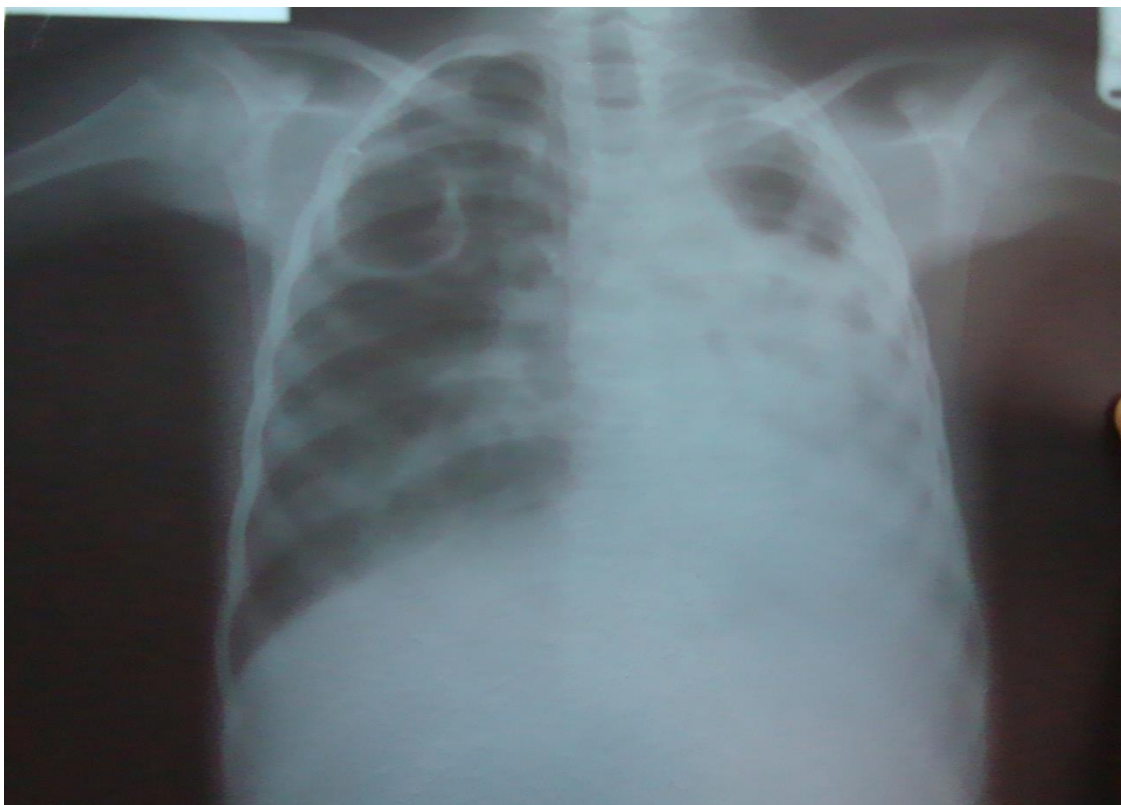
Chest radiograph of a 12-year-old HIV-infected child with MDR TB. Note the cavity on the right upper zone.
